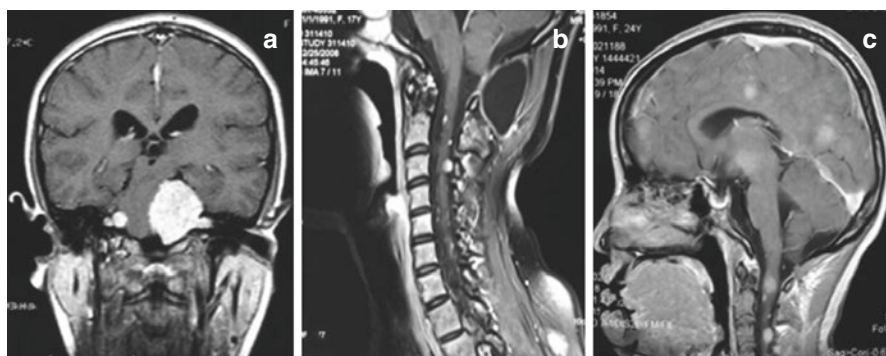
The cranial (a) and cervical spinal cord (b) MRI of a 17-year-old girl with NF2, which clearly show bilateral vestibular schwannomas and multiple spinal schwannomas, respectively. Image from 7 years later (c), which shows multiple intracranial meningiomas and progress of the spinal schwannomas
